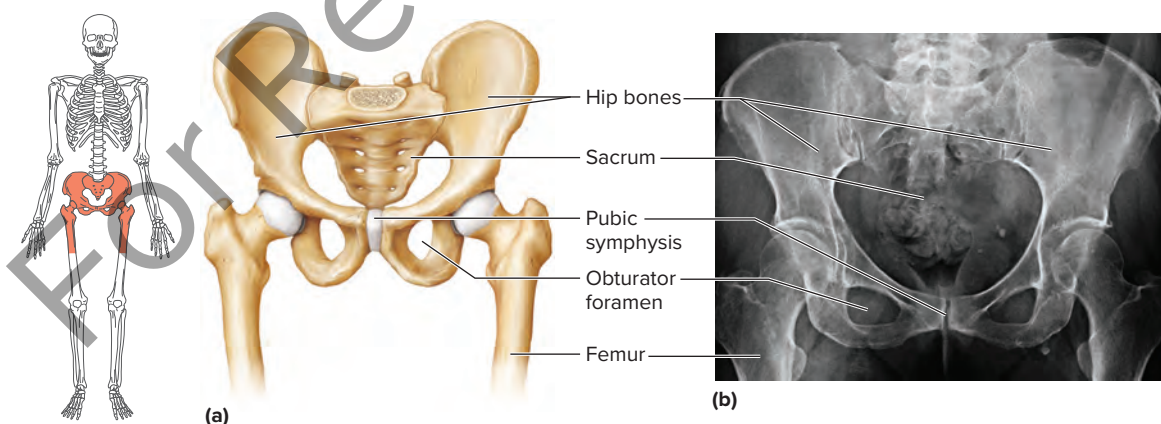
Pelvic girdle, anterior view. (a) The pelvic girdle is formed by two hip bones. The pelvis includes the pelvic girdle, as well as the sacrum and the coccyx. (b) A radiograph of the pelvic girdle showing the sacrum, coccyx, and proximal ends of the femurs.
